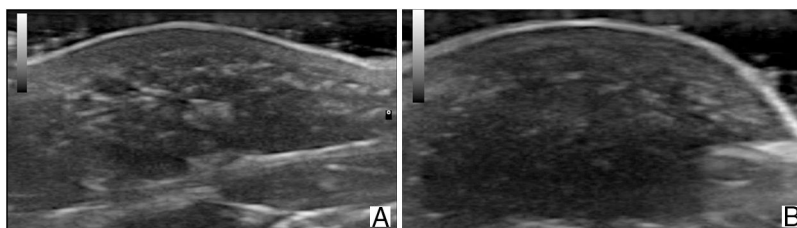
Ultrasound image (18 MHz) of fibrolipomatous hamartoma. A, Longitudinal plane (A). B, Transversal plane (B). Note the thickening of the dermis and hypodermis at the expense of hypoechoic islands with fatty echogenicity intermingled between hyperechoic lines in the deep dermis, which extend to the subcutaneous cellular tissue.
